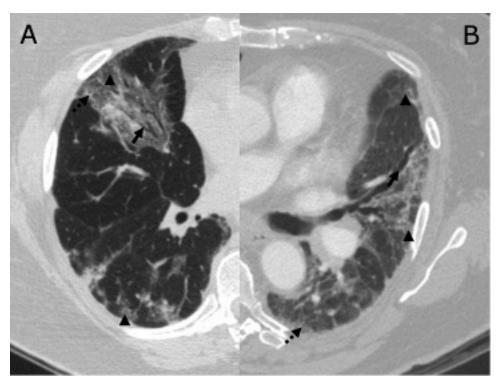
High-resolution computed tomography of patients with anti-ARS (A) and antiPM/Scl antibodies (B) showing traction bronchiectasis (arrow), reticulation (broken arrow), ground-glass attenuations (arrowheads), and absence of honeycombing. The imaging pattern is suggestive of nonspecific interstitial pneumonia.
